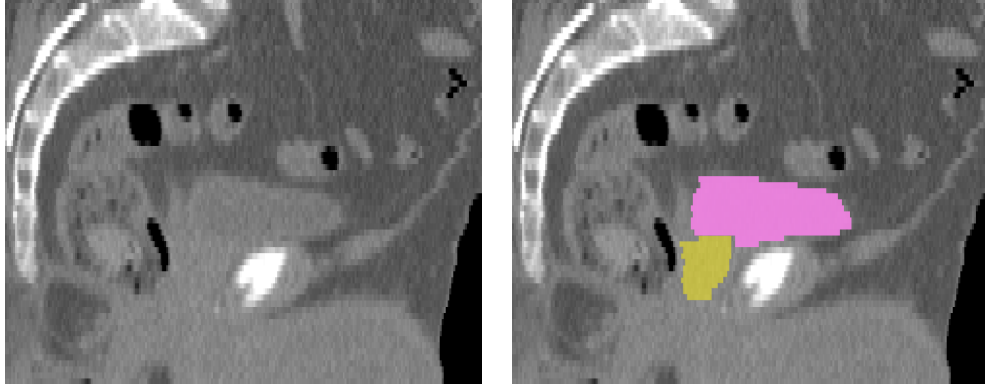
Example sagittal CT slice of the male pelvis (left), with the bladder and prostate highlighted (right). Note the lack of contrast around the organs of interest.
